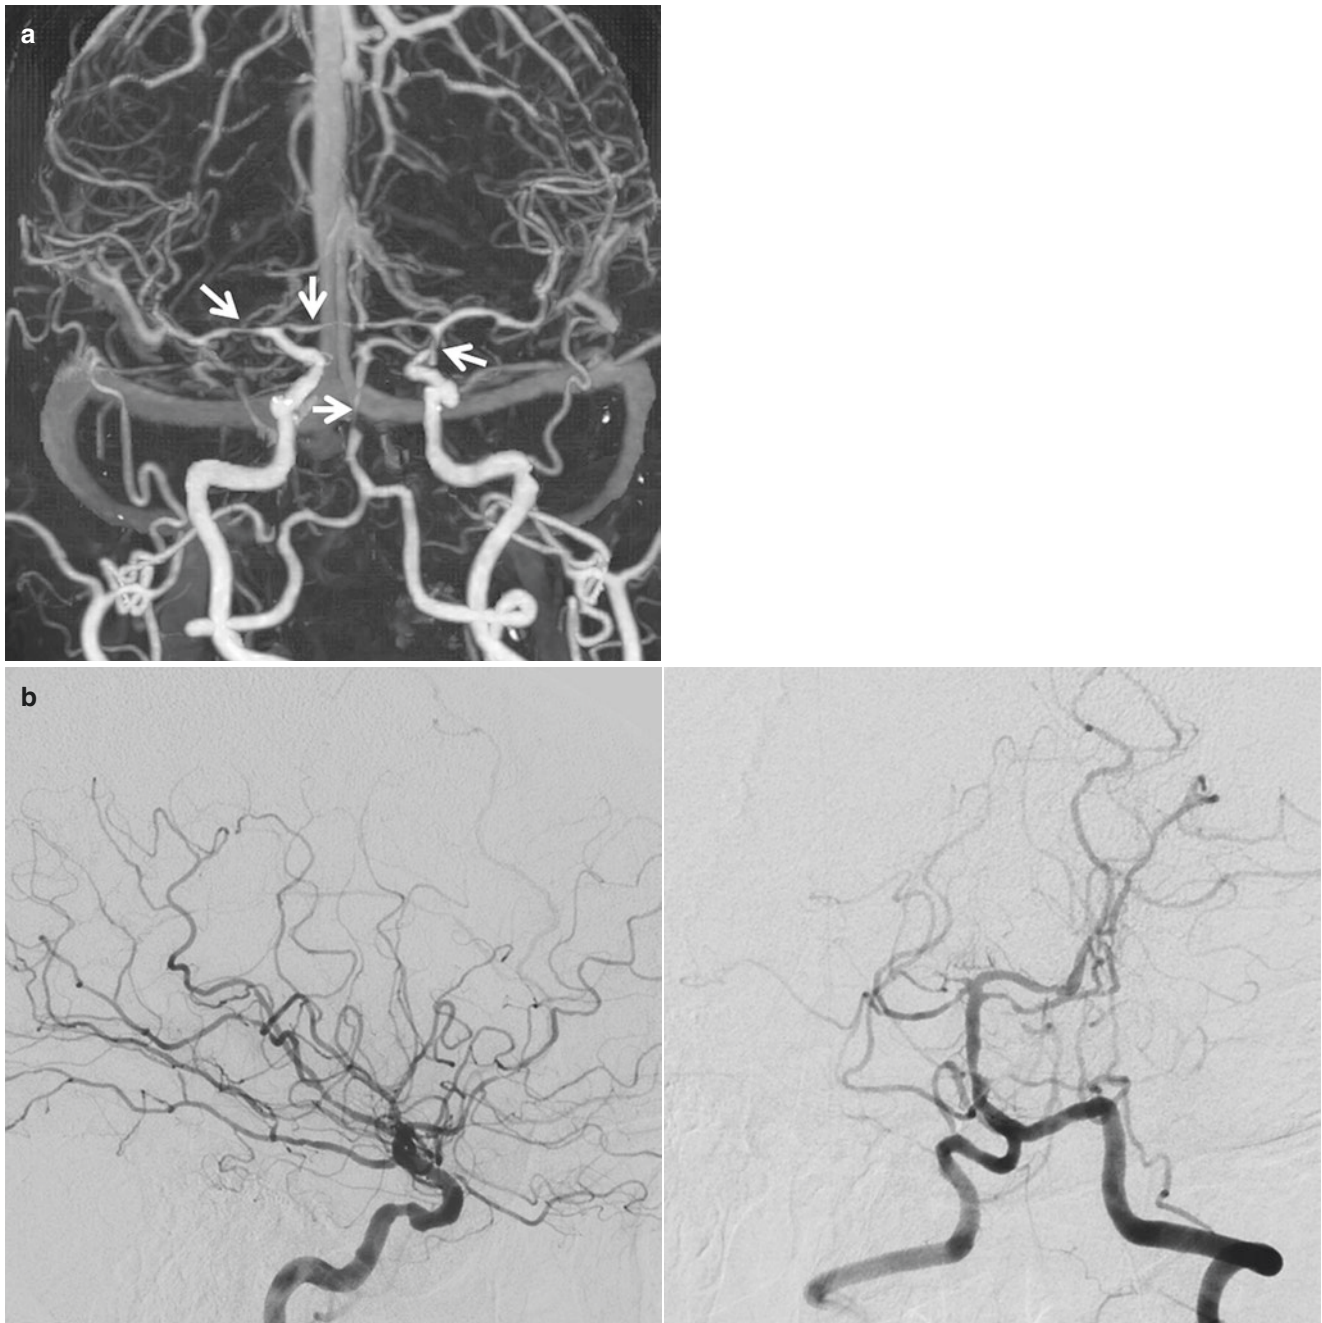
Cocaine-induced vasculopathy. Patient with history of cocaine abuse presents with subarachnoid hemorrhage. (a) 3D CTA MIP image shows multifocal stenosis involving anterior and posterior circulation
